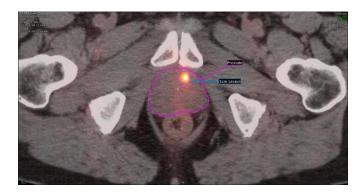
Transaxial Image of PSMA PYLARIFY® PET/CT Showing 1 cm Rounded Lesion in Prostate
